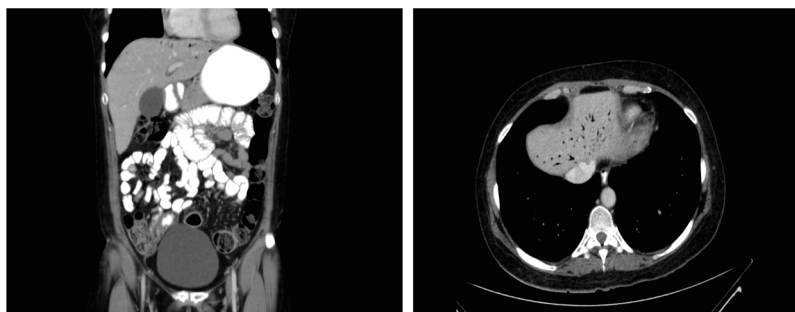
Computed tomography (CT)-scan images at diagnosis of HPVG. (a) Axial reconstruction. (b) Coronal reconstruction. Portal vein gas is predominantly located within the left hepatic lobe in both CT-scan images. Air bubbles appear to extend within 2 cm of the liver capsule.
